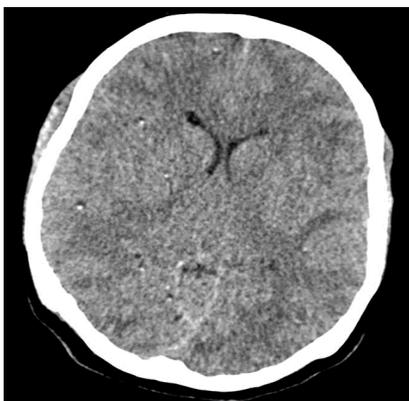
CT axial section at the level of lateral ventricles.
